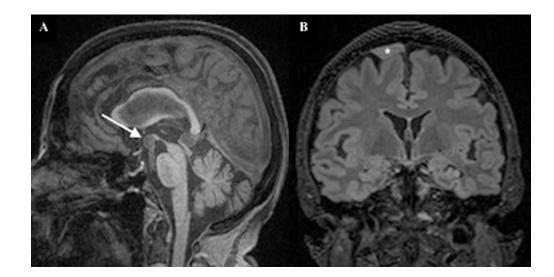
(A) Sagittal T1-weighted image, demonstrating a 10mm aneurysm (arrow) arising from tip of the basilar artery. (B) Coronal FLAIR image, demonstrating a broad-based extra-axial lesion (asterisk) overlying the right superior frontal gyrus, consistent with a meningioma.
